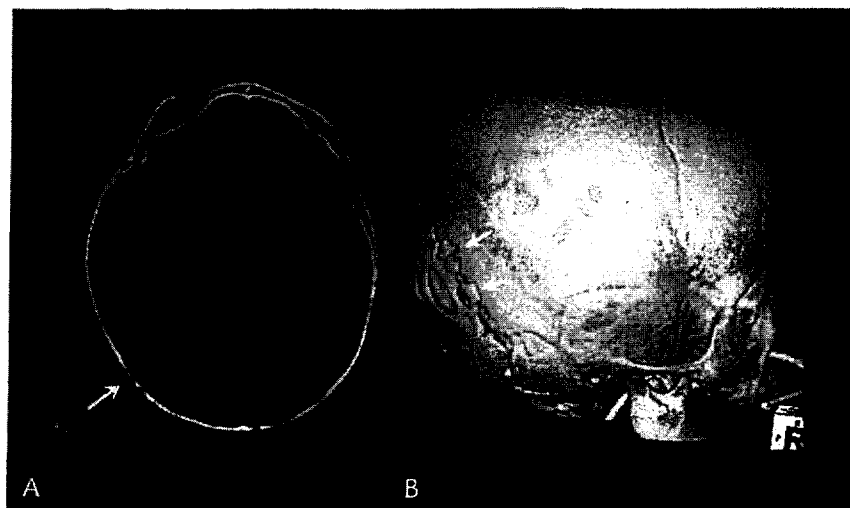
Images obtained from a 10-month-old male infant with intrasutural (wormian) bones versus fractures. A, CT image shows right-side parietal cranial defects (arrow). B, Three-dimensional computed tomographic surface reconstruction confirms intrasutural bones (arrows).
